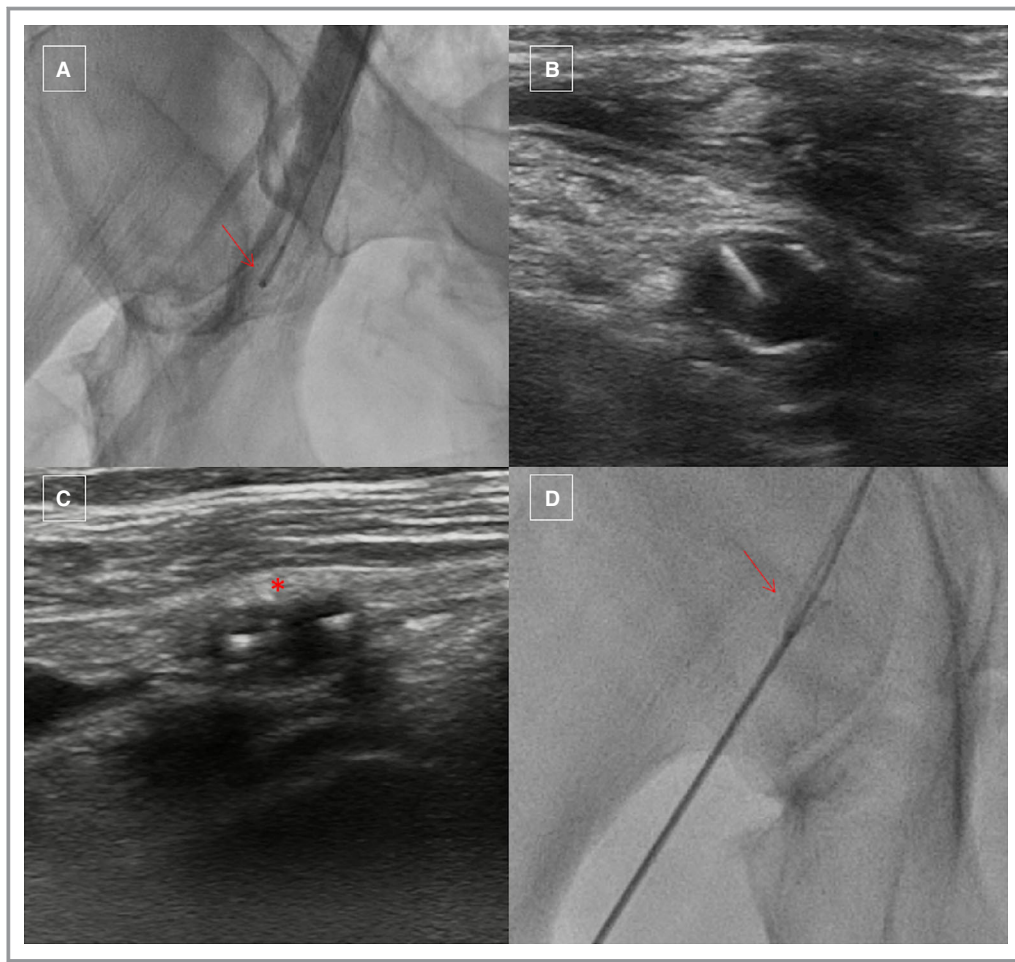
The angiographic, guidewire, and ultrasound (AGU) technique for vascular management. The J tip of the 0.035-inch guidewire is placed, under fluoroscopic guidance, in the ideal femoral artery spot (above the bifurcation) (A). The J tip of the 0.035-inch is identified using ultrasound imaging (B). The femoral artery puncture is performed under ultrasound guidance. The asterisk indicates the needle penetrating the anterior wall of the femoral artery (C). Site of sheath insertion (D).
